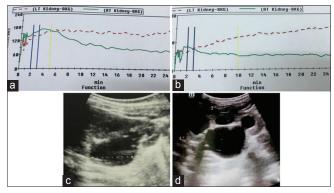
(a) Diethylenetriaminepentaacetic acid (DTPA) scan done at the age of 1 year shows obstruction of the left kidney, (b) ultrasonography done at the age of 1 year shows AP diameter of 20 mm, (c) DTPA scan done at the age of 2 years shows persistent obstruction of the left kidney, and (d) ultrasonography done at the age of 2 years shows AP diameter of 22 mm and Society for Fetal Urology Grade 3 hydronephrosis
